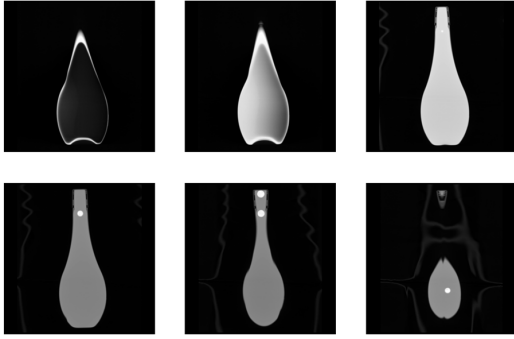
Six CT segments of “Blue large BB” in frontal view.
